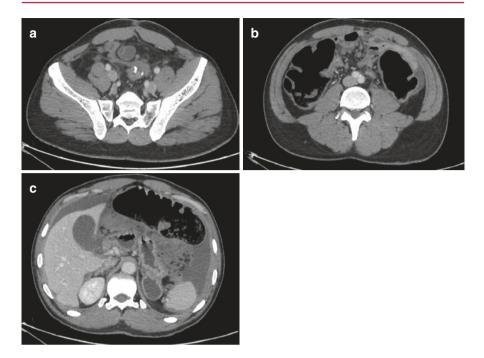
(a–c) CT imaging of a patient with left colonic obstruction for peritoneal carcinomatosis. (a) Peritoneal carcinomatosis causing colic obstruction in a patient with previous left colectomy. (b) Cecum dilatation for colic obstruction. (c) Colic dilatation and ascites for colonic obstruction for peritoneal carcinomatosis
